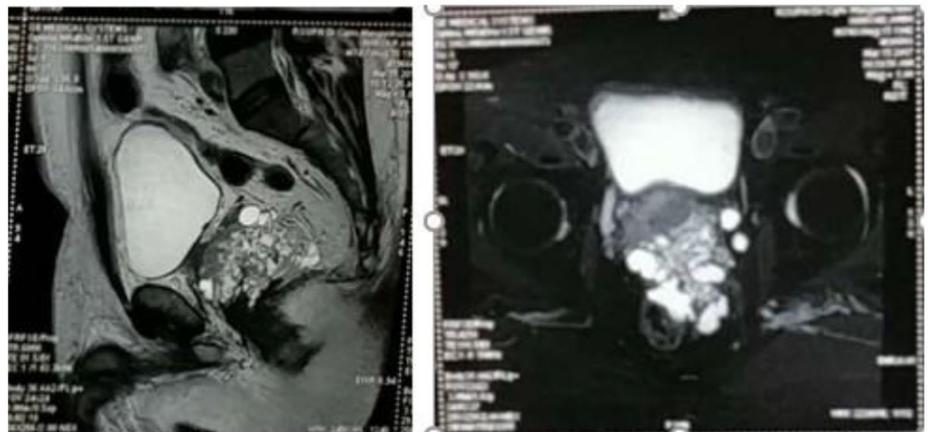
MRI of prostate demonstrated enlarged prostate with suggestively malignancy
